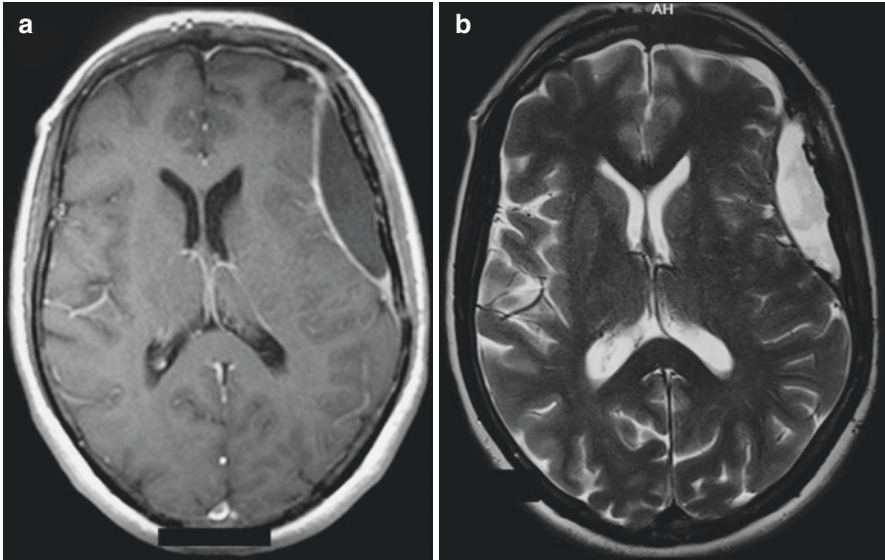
Axial cranial T1-weighted MRI after gadolinium administration (a) and on T2-weighted MRI (b) revealing a frontal extradural empyema on the left side
